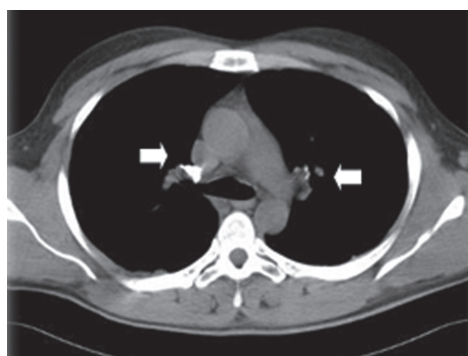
Pre-contrast agent infusion computed tomography scan. Hyperdense material evident in the right pulmonary artery and also in different segmental and subsegmental branches of both lungs
